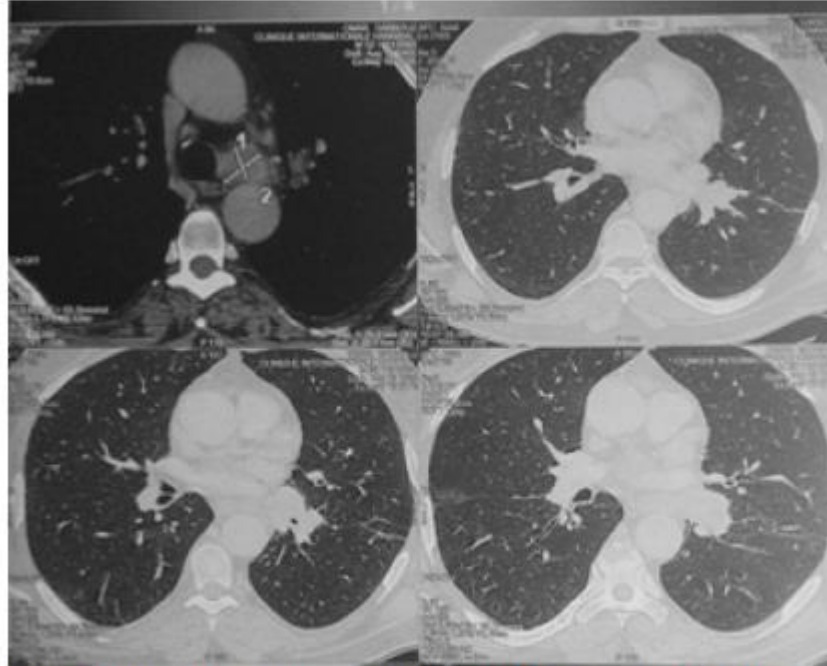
Thoracic CT shows a tumor mass that obstructs the left lower lobe bronchus with left hilar and sub-carinal adenomegalies.
